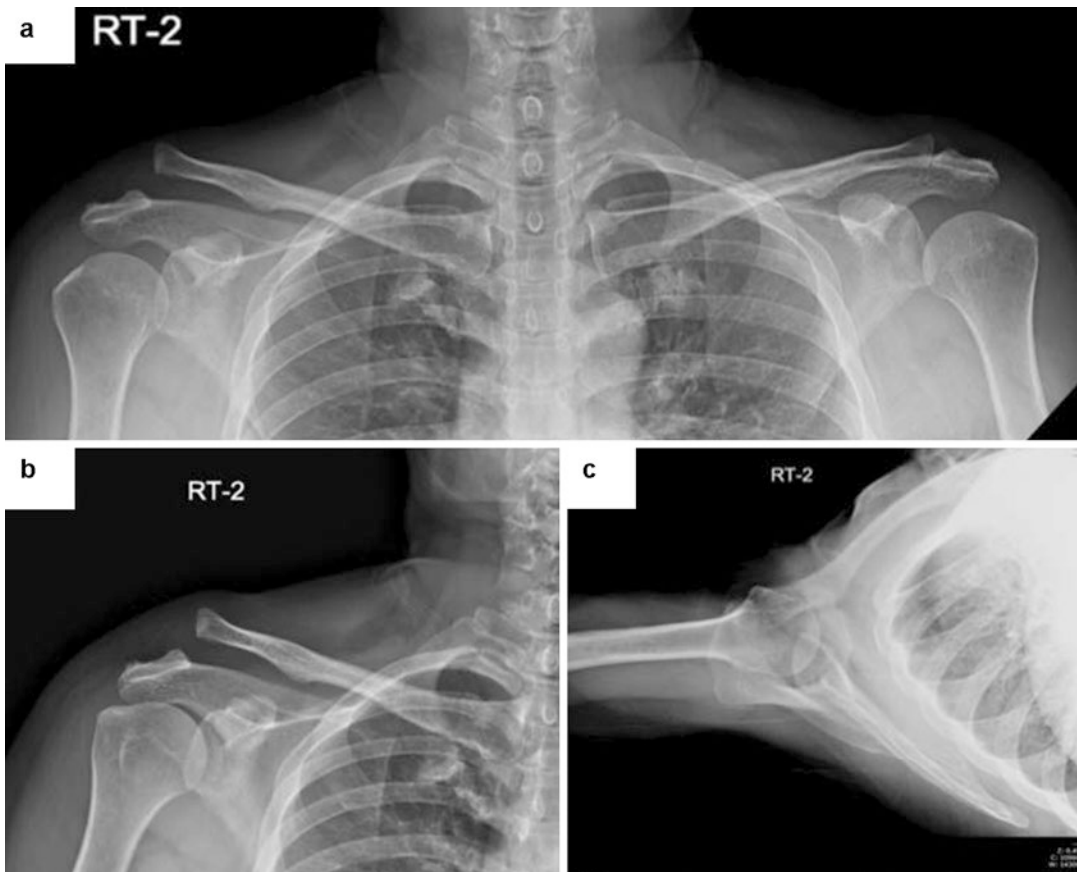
Preoperative radiograph of a patient showing AC joint dislocation
